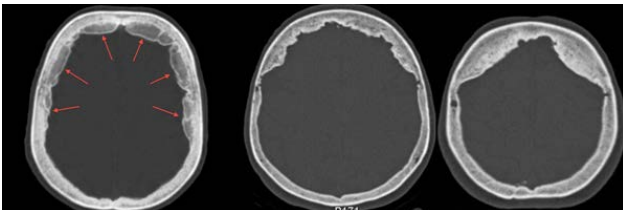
Skull CT, bone window. Internal frontal table bone appositions with symmetrical and radial disposal and mamelon-like borders.
